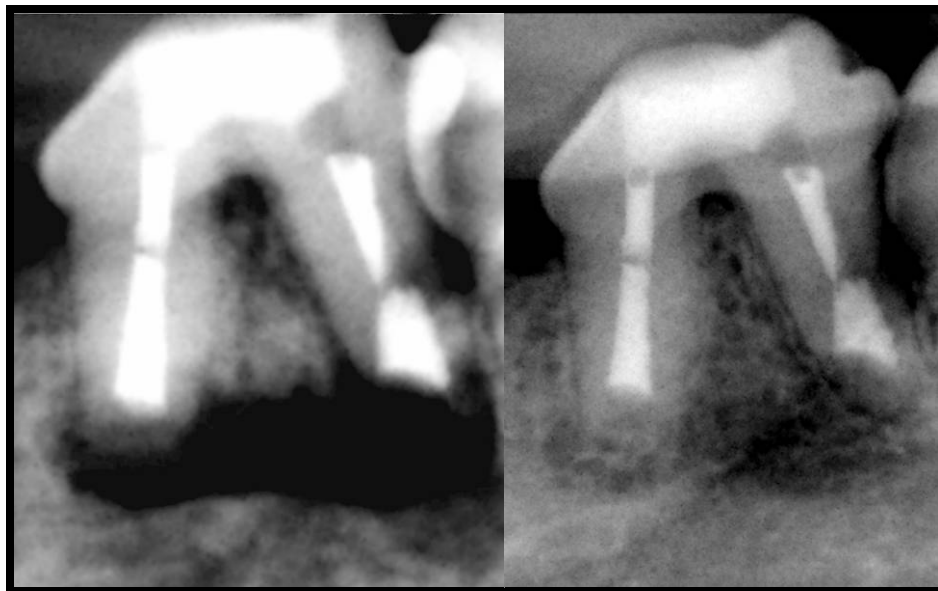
“MTA tooth” radiographs post-surgical vs. 6 month follow-up 2
